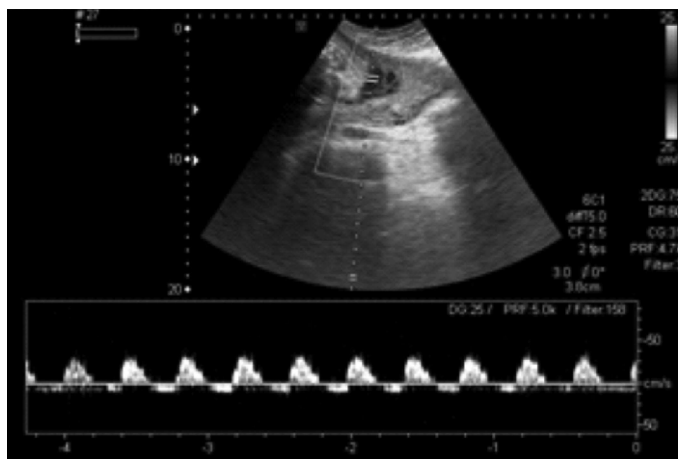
Reversed end diastolic flow (REDF) of Umbilical Artery Doppler in IUGR Positive case
